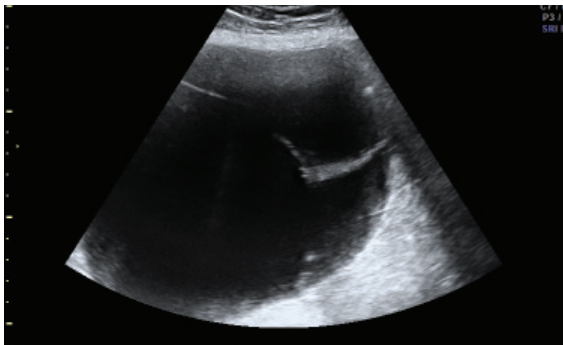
Ovarian cyst at ultrasound. Courtesy of Mirjam Weemhoff
